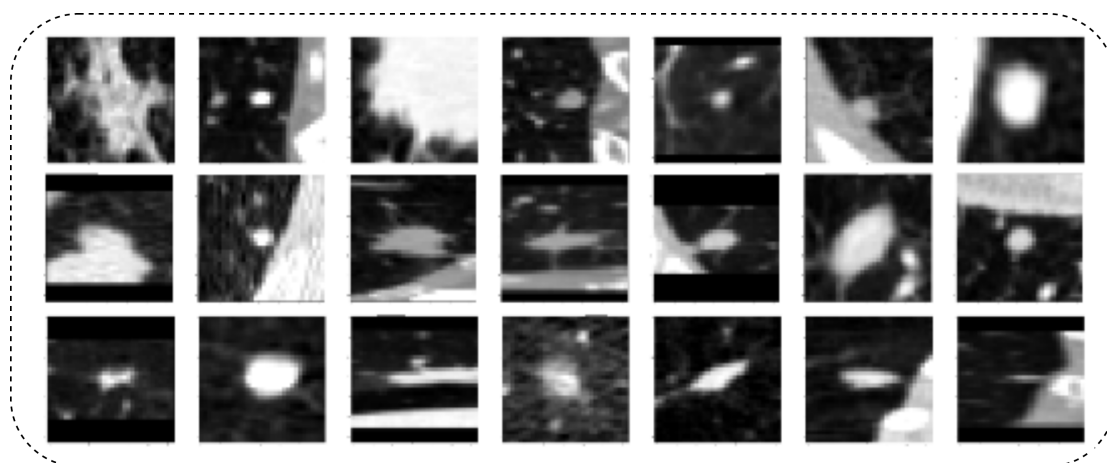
Augmented images of a nodule CT scan
